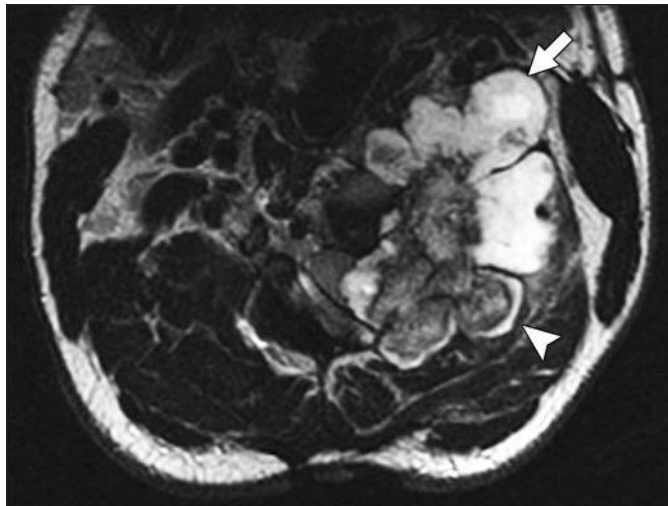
32-year-old man with cervical osteochondroma showing growth and increased pain over prior 6 months. Axial T2-weighted (TR/TE, 6566/117) MR image shows osteochondroma along left lateral cervical spine. Note thin cartilage cap posteriorly (*arrowhead*) and thickened cartilage cap anteriorly (> 2 cm) representing secondary chondrosarcoma (*arrow*).
